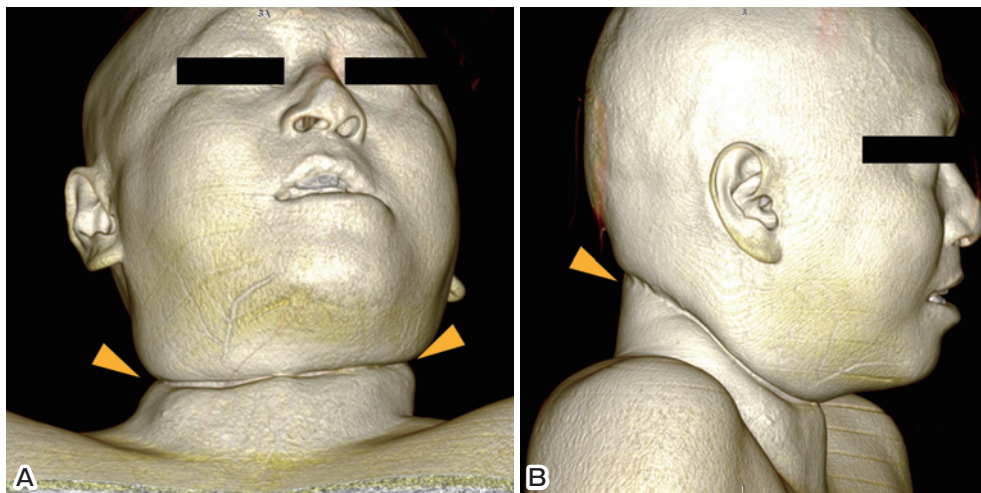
Postmortem computed tomography (CT) 3D-volume-rendering images showing a ligature mark around the neck of the decedent; anterior (A) and lateral (B) views.
